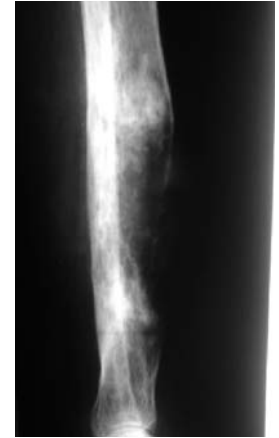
Plain radiographs showing areas of osteolysis
